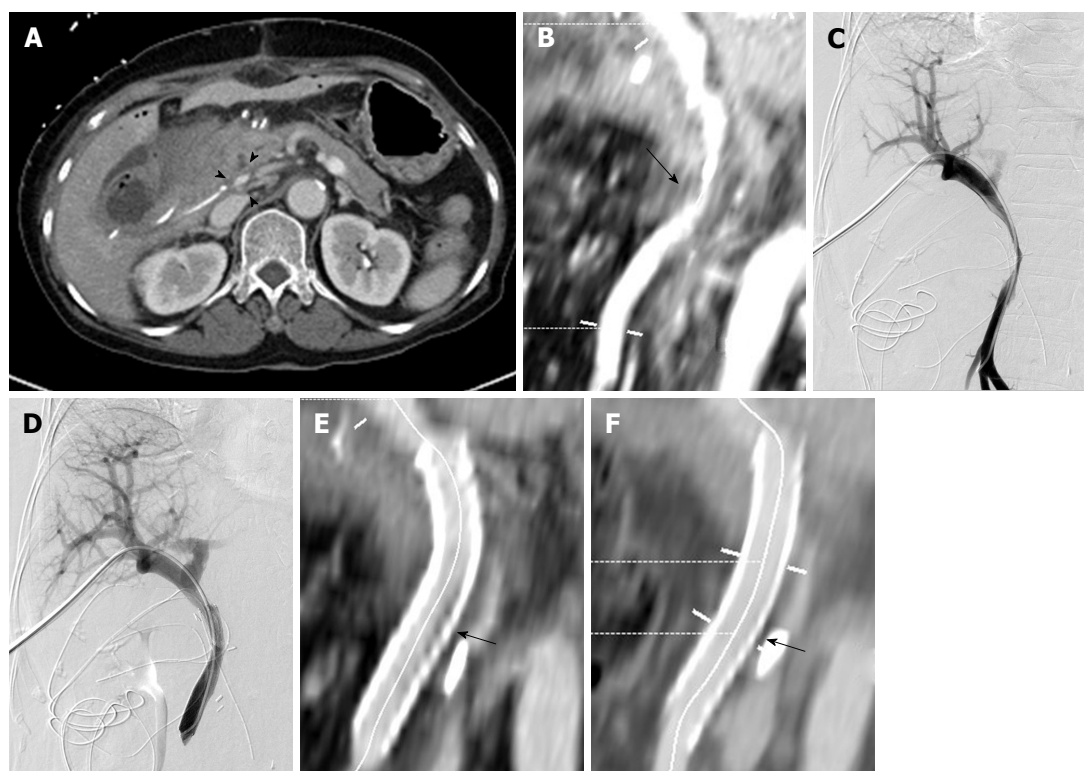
A 68-year-old woman (patient No. 8) presenting with main portal vein stenosis after pylorus-preserving pancreatoduodenectomy for duodenal gastrointestinal stromal tumor. She presented with anorexia and increased JP drain output during the follow-up period. A: Axial CT image 13 d after surgery showing stenosis at junction between the PV and SMV (arrowheads); B: Curved planar reformatted (CPR) image from abdominal CT 13 d after surgery showing stenosis at junction between the PV and SMV (arrow); C: Percutaneous transhepatic portogram showing severe stenosis (> 50%) at the PV-SMV junction. The pressure gradient was not measured because of definite stagnation of the contrast medium. The contrast medium injected at the distal SMV is clearly stagnant; D: Portogram showing metallic stent in the main PV and SMV and the elimination of stenosis. After the procedure, the patient's symptoms and signs improved; E: CPR image from abdominal CT 2 d after stenting showing patent stent with small in-stent low-density area (arrow); F: The extent of small in-stent low-density area decreased on CPR image from abdominal CT scan 555 d after stenting (arrow). CT: Computed tomography; PV: Portal vein; SMV: Superior mesenteric vein.
